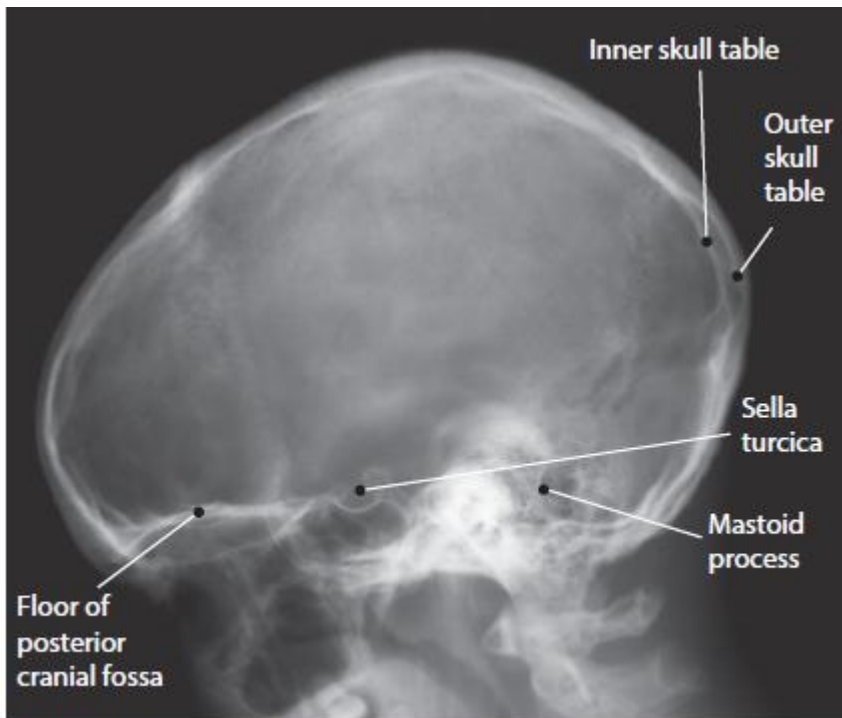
Lateral radiograph showing anatomical features.
